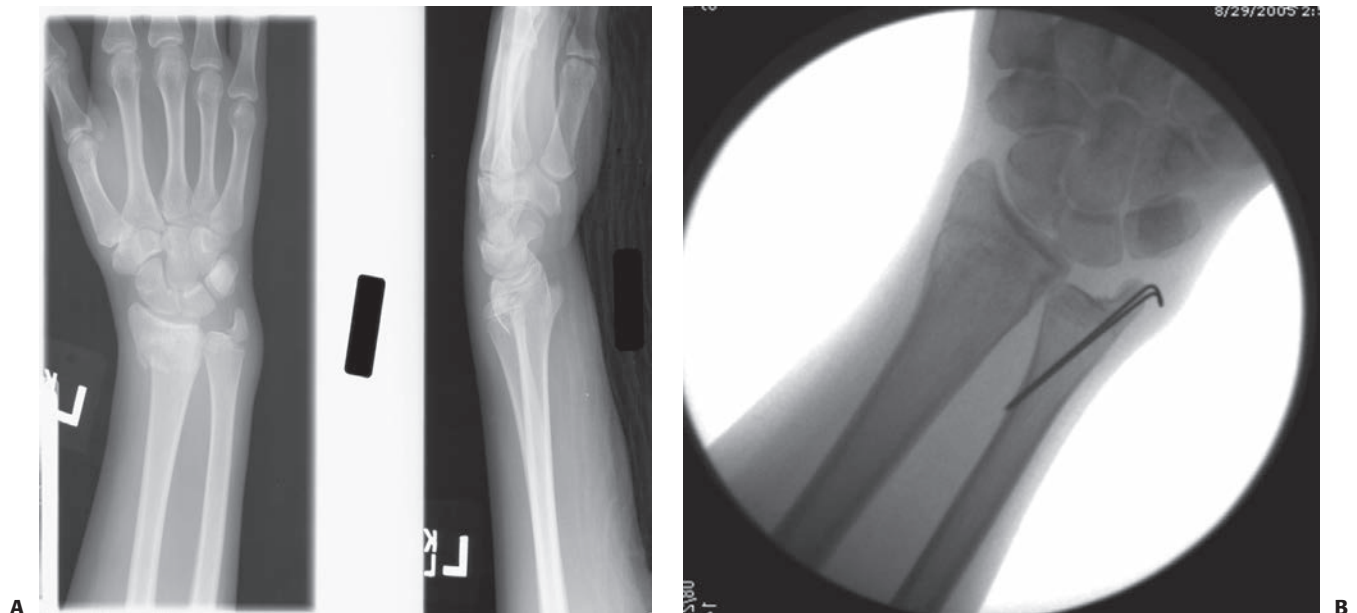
A: Plain radiographs depicting displaced distal radial metaphyseal and ulnar styloid fractures. Given the fracture and distal radioulnar joint instability, the injury was treated with closed reduction and percutaneous pinning of the distal radius as well as open reduction and tension band fixation of the ulnar styloid. B: Follow-up radiograph following reduction and fixation demonstrate anatomic alignment. The prior radial pins have been removed, and the parallel smooth wires used for tension band fixation of the ulnar styloid are seen.
